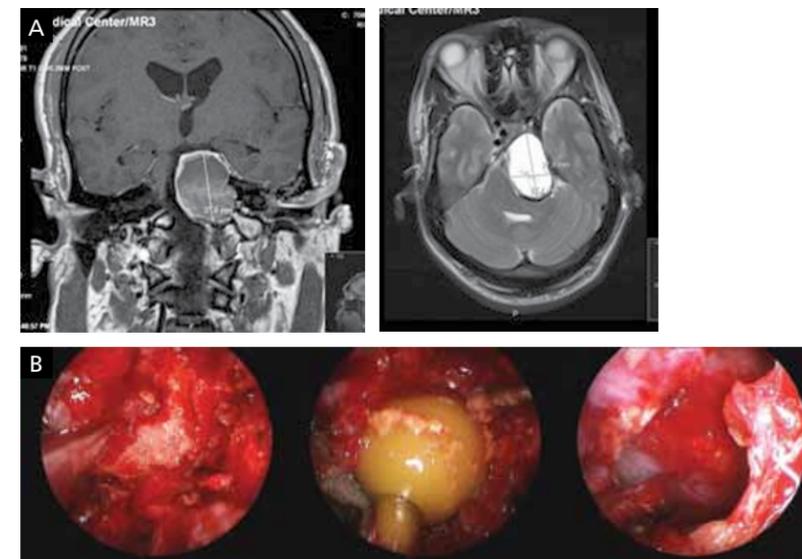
(A, left) Coronal T1-weighted and (A, right) axial T2-weighted magnetic resonance images of a 50-year-old man with a history of diplopia and severe headaches, demonstrating a large petrous apex cholesterol granuloma. Previous drainage attempts via a transtemporal approach were unsuccessful in adequately draining the lesion. (B, left) After removal of the upper clivus and posterior wall of the sella (B, center), excellent visualization of the cyst and drainage of its contents can be performed through a transnasal endoscopic approach. (B, right) After the cyst is drained, the posterior wall of the lesion comes into view with the dural margins.
